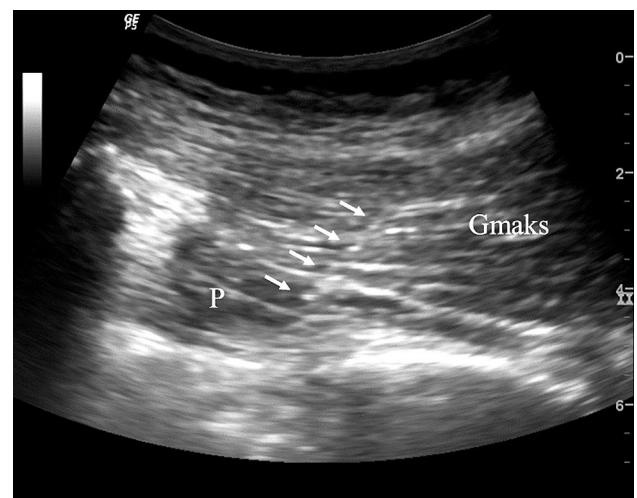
Piriformis muscle injection under ultrasound guidance with in-plane technique.
